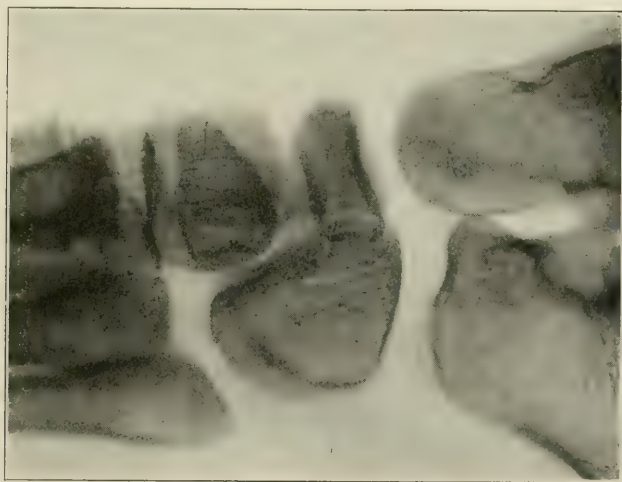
Diseased foot: Recovery advanced, scaphoid regaining normal size, shape and roentgen-ray appearance. (Risser.)
